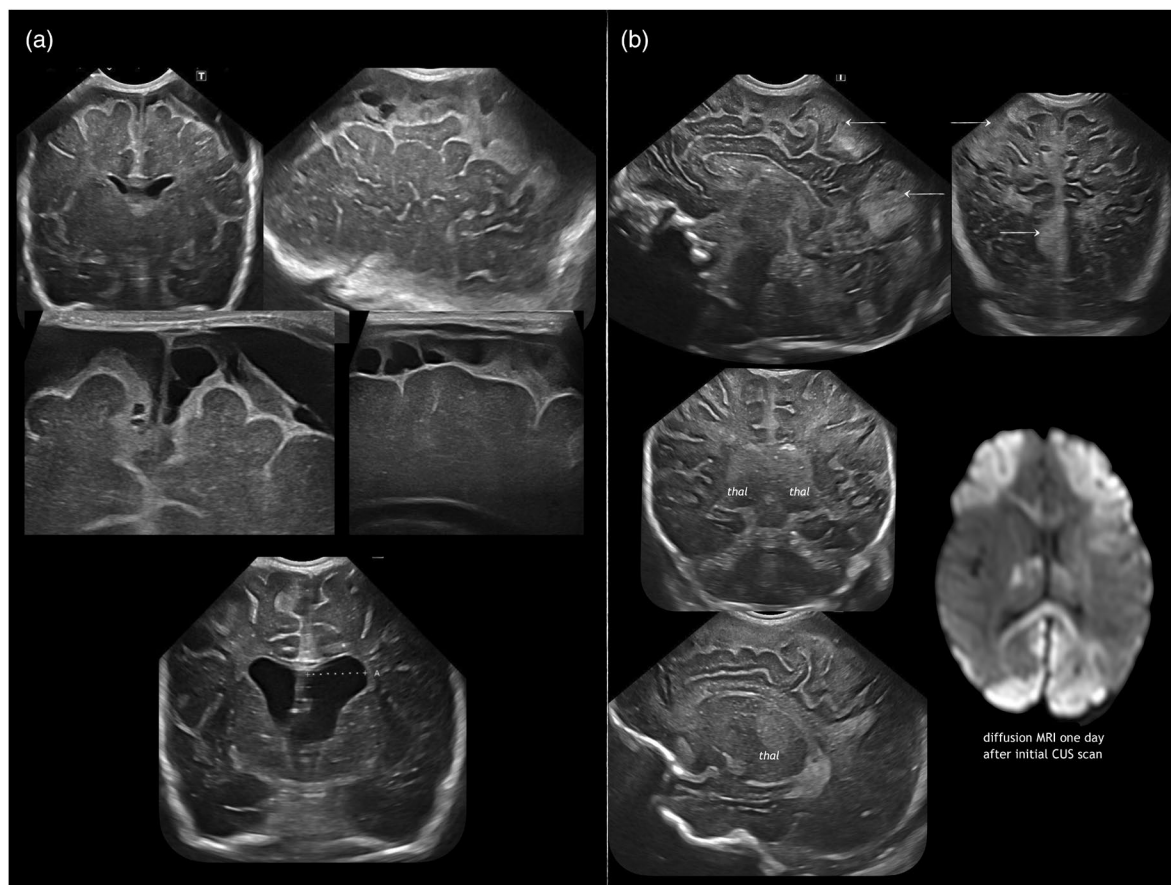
Late-onset group B *Streptococcus* meningitis: leptomeningitis with subcortical infarction. (a) Infant born late preterm with late-onset GBS meningitis, prolonged antibiotic therapy; (sub)acute images: extensive subdural collections, arachnoiditis and meningeal thickening; cranial ultrasound at term (below) shows resolution of the subdural collections and ventricular dilatation which stabilized spontaneously afterwards. (b) Term-born infant with late-onset GBS meningitis: on day of admission hyperechoic inflammatory collections are suspected in and around the frontoparietal and occipital cortex, there is an increase of echogenicity in both thalami; the diffusion-weighted MRI (right) confirms the stroke-like lesions in the cortex and both thalami. Abbreviations: GBS, group B *Streptococcus*; MRI, magnetic resonance imaging; thal, thalami.
